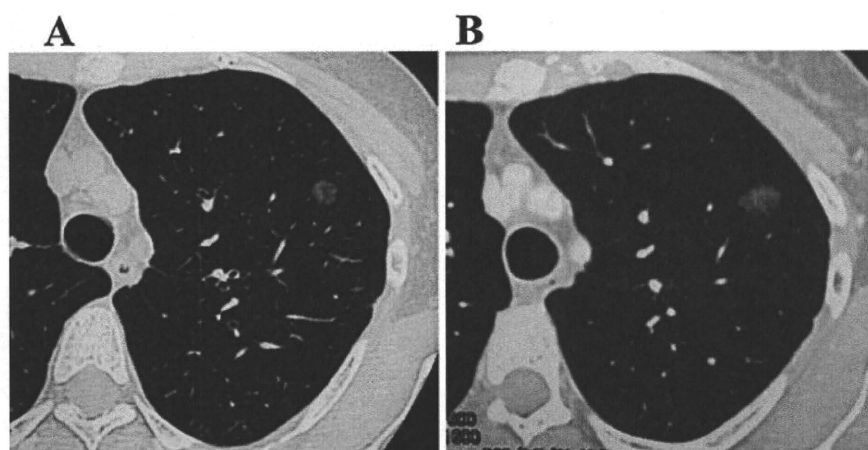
Computed tomography images from a 41-year-old woman. A Thin-section CT scan showing a pure GGO 10 mm in diameter in the left upper lobe of the lung. B At the 51-month follow-up, the diameter of the lesion had increased to 15 mm
